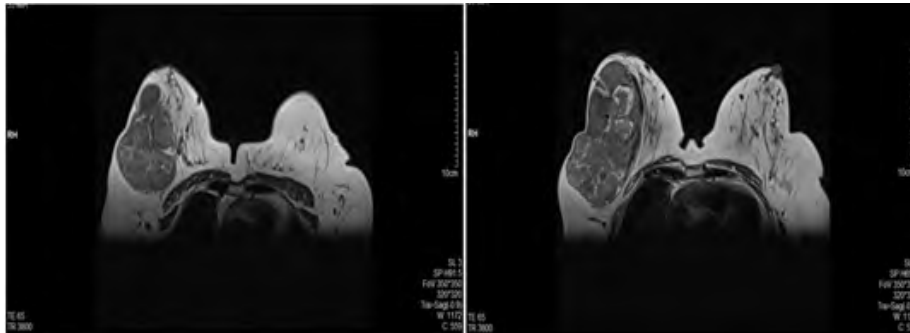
MRI with gadolinium contrast that reveals a solid mass-like lesion with circumscribed edges that measures 12.5 x 8.5 x 7 cm (AP x L x T).
